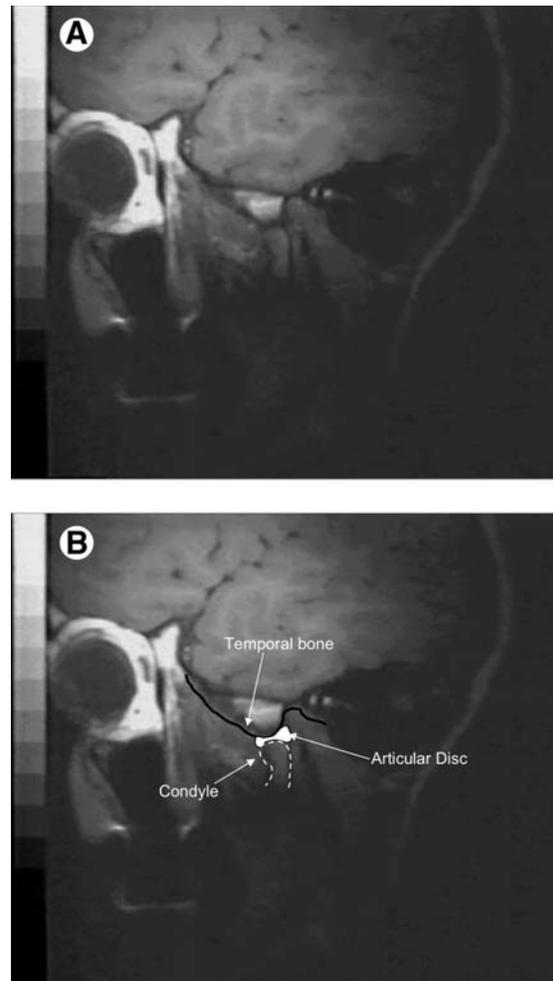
(A) The MRI image of a normal TMJ at an open mouth position presents well-defined pterygoid muscles, an articular disk in proper position, and normal condyle-temporal bone relationship. (B) Outline and labels for A.
